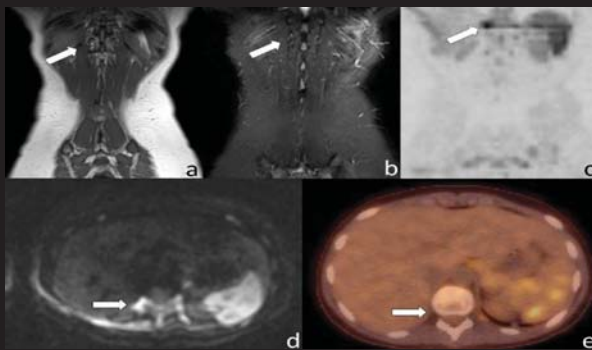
Artifact near the diaphragm in a 15- year old girl with Hodgkin lymphoma stage IV. a.T1, bSTIR, c.DWIBS, d.axial DWI b=1000 (source image for DWIBS) and e.fused 18F-FDG-PET-CT image. The right paravertebral high signal on DWI just below the diaphragm on DWIBS (arrow) was not identified on anatomic MR-images and 18F-FDGPET- CT. Possibly this artifact is due to movement, although the cause of this artifact is not entirely clear.
